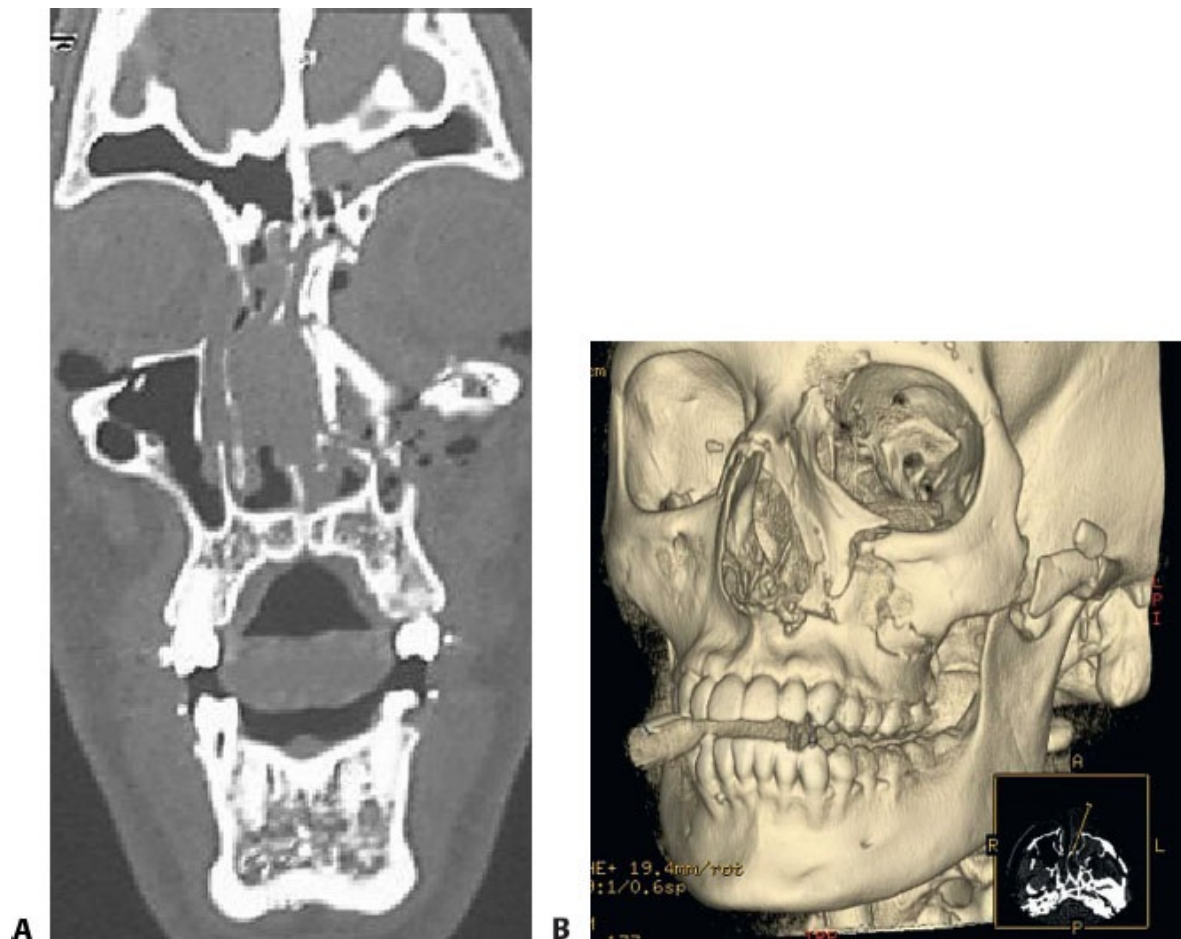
• A. Coronal CT hemi–Le Fort II NOE fractures.
